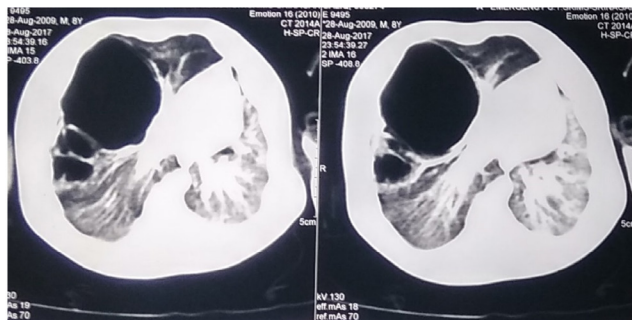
CT chest showing large cyst in right upper lobe congenital pulmonary airway malformation
